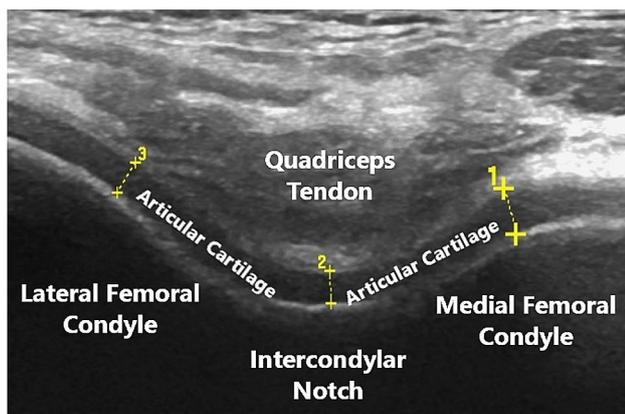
Ultrasonographic image of femoral cartilage: femoral cartilage thickness was measured as the length of the straight line drawn from the cartilage–bone interface to the synovial space–cartilage interface. 1. Medial femoral cartilage thickness, 2. intercondylar cartilage thickness, and 3. lateral femoral cartilage thickness
